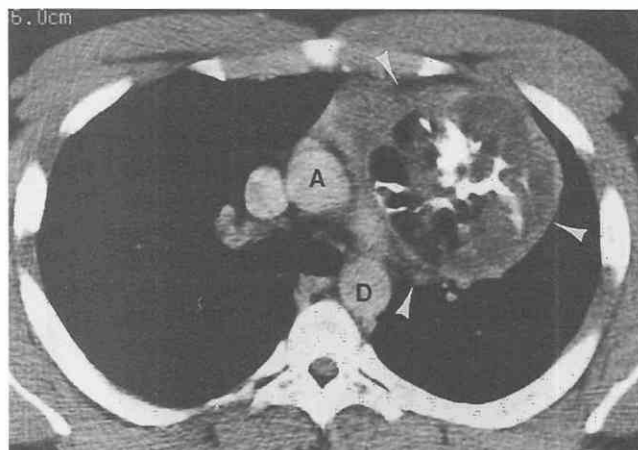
Mature teratoma. Contrast-enhanced CT shows large anterior mediastinal mass (arrowheads). The mass, which is composed of fat, calcium, and fluid, is heterogeneous in attenuation. The CT appearance is typical of a mature teratoma. A, ascending aorta; D, descending aorta.
